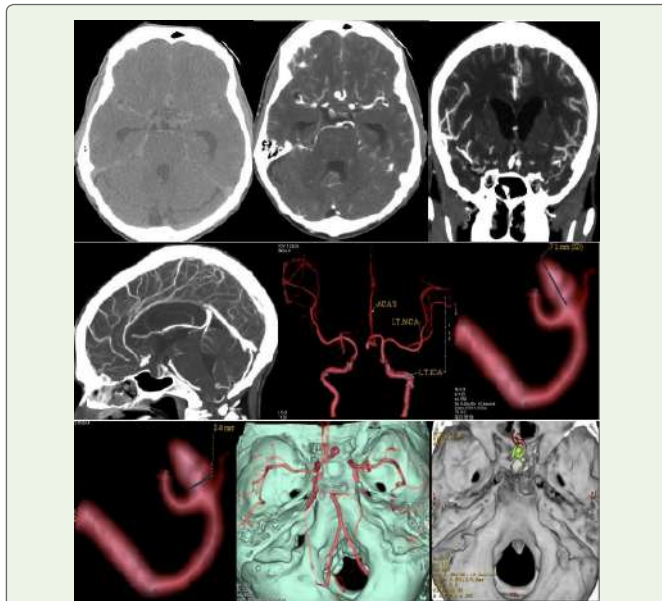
Noncontrast CT (A), shows acute SAH. A medium saccular aneurysm of ACOM with a neck diameter of 3.4 mm is visible on CTCA (B-D), 3D-VR pictures (E-G), and 3D-VR virtual dissection (H, I). Endovascular coiling and/or surgical clipping were recommended for him.
